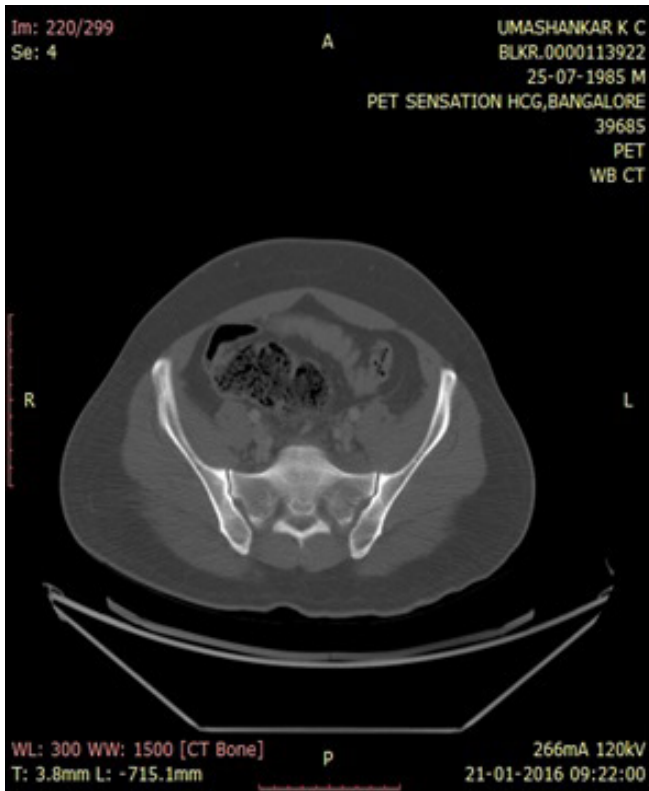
Pretreatment FDG- PET/CT imaging suggestive of vertebral lesion.
